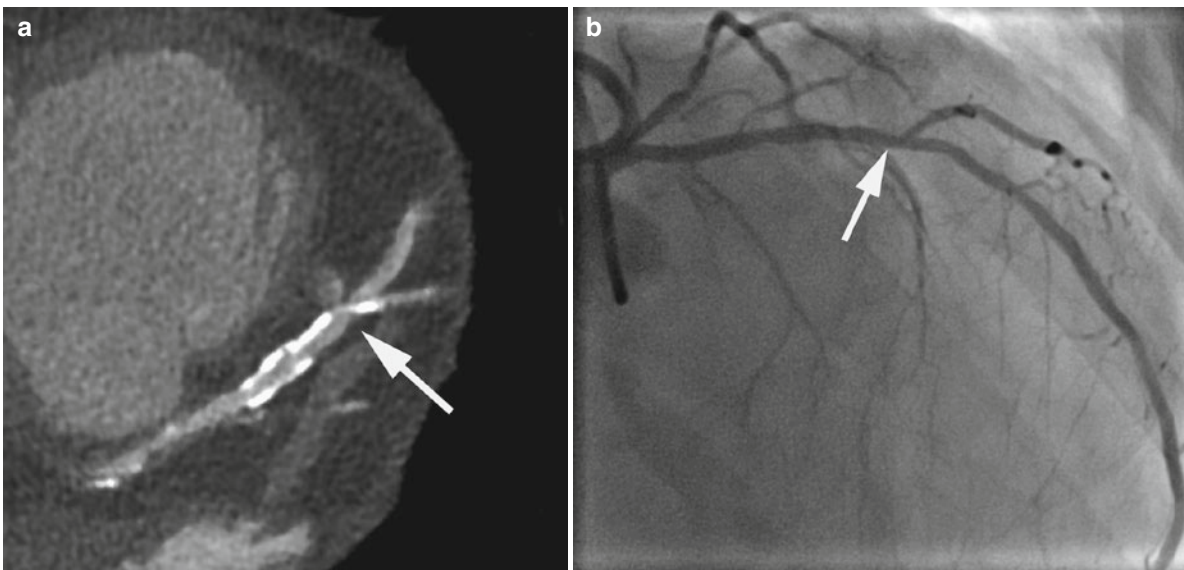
Image quality in coronary CT angiography is not always impeccable. Suboptimal image quality can lead to false-positive (and less frequently, false-negative) interpretations of coronary artery stenoses. The most frequent reasons for false-positive findings are small vessel diameters, high
